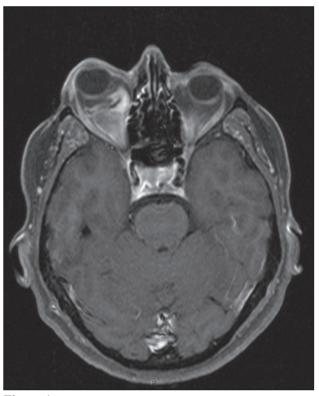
An MRI scan showing liposarcoma of right orbit
